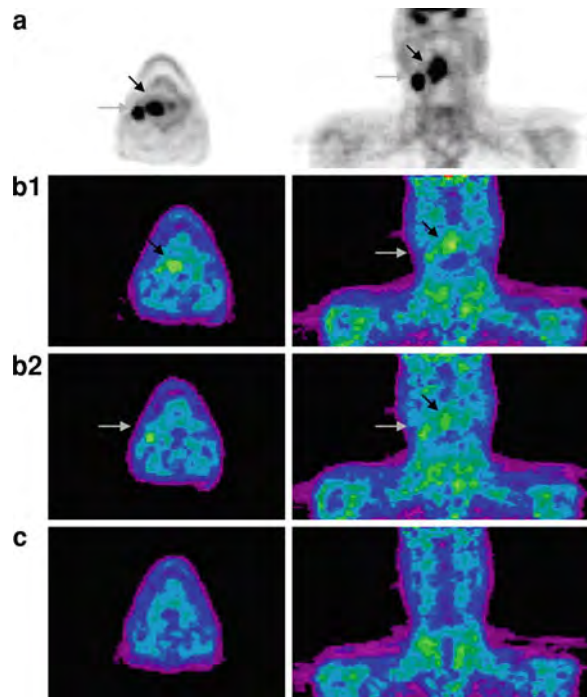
Temporal change in hypoxia. A 57-year-old patient presented with stage T3N2b squamous cell carcinoma of the oropharynx. Baseline ^{18}F -FDG PET (a) shows uptake at the primary tumour (black arrow) and regional lymph node (grey arrow). ^{18}F MISO PET acquired 1 day later (b1–2) indicates hypoxia in both the primary tumour (b-1 black arrow) and lymph node (b-2 grey arrow). Repeat ^{18}F MISO PET after 4 weeks of radiotherapy (c) shows decreased ^{18}F MISO uptake
